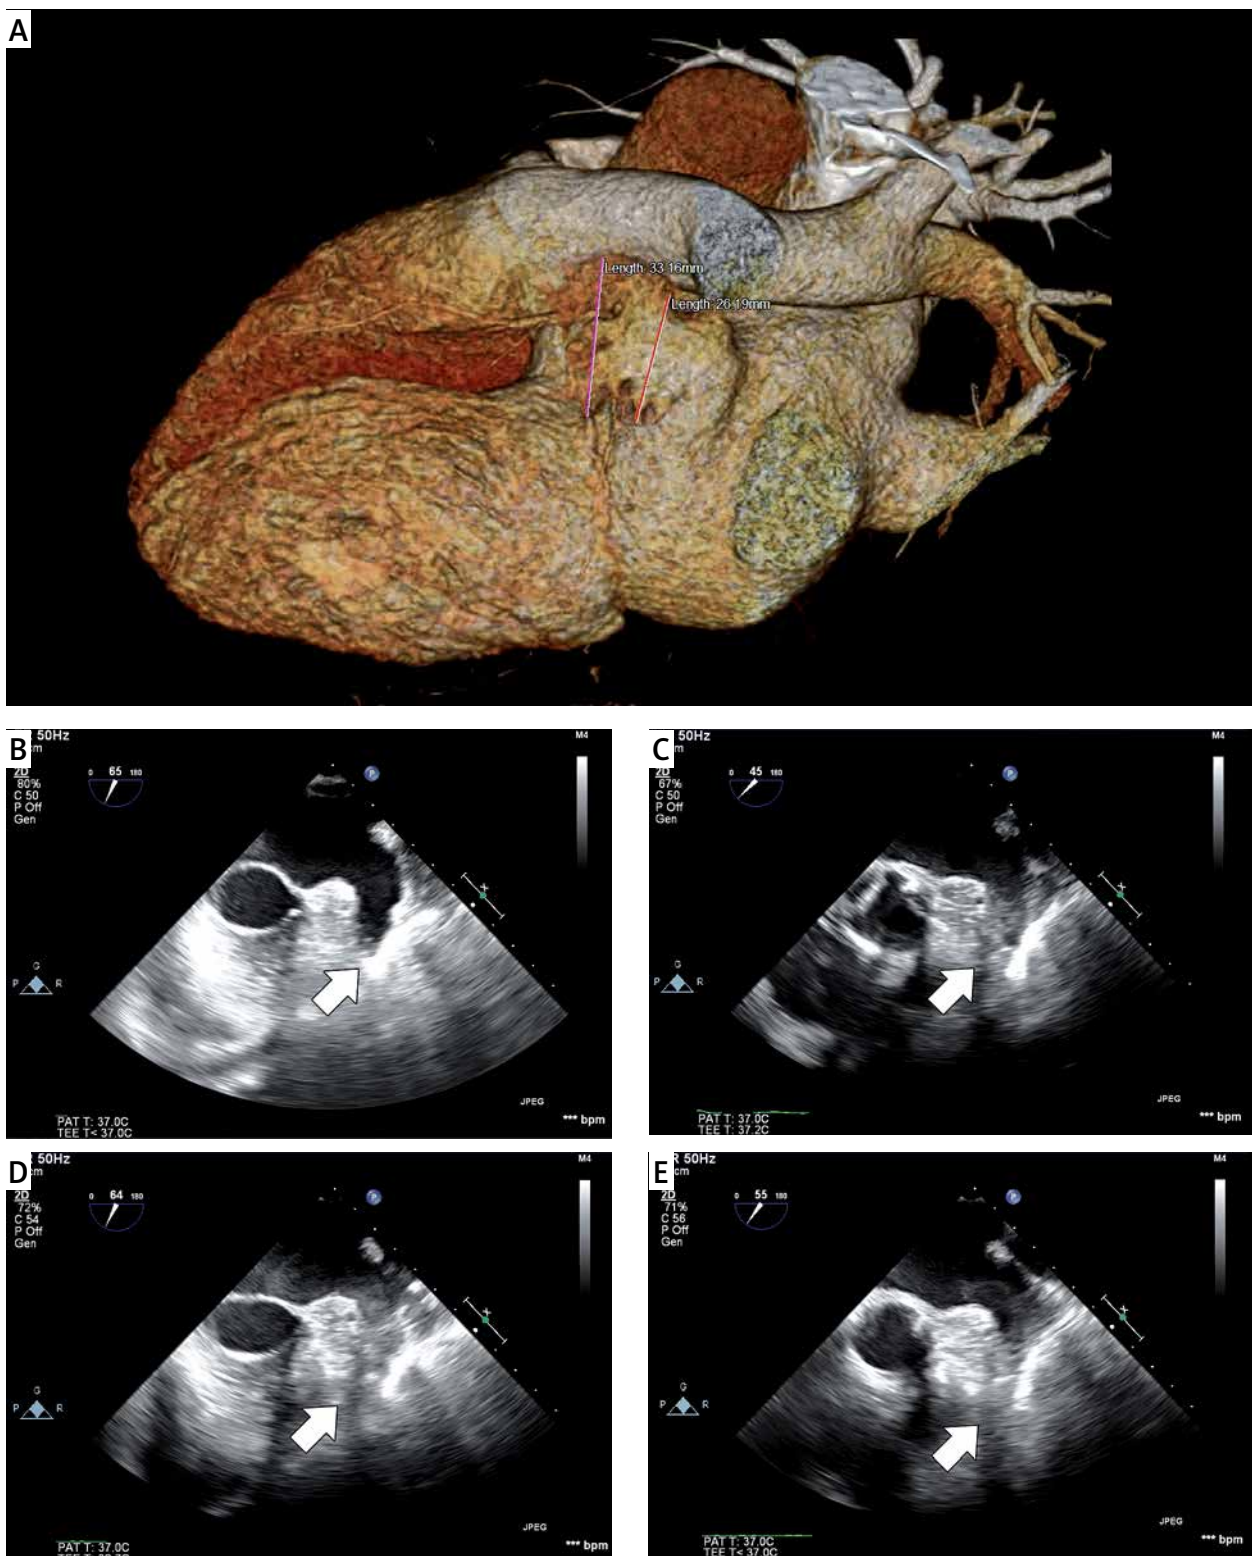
A – 3D computed tomography reconstruction scan with measurements of the left atrial appendage (LAA), B – transesophageal echocardiogram (TEE) at 3:57 PM with no thrombus in LAA (arrow), C – TEE at 4:27 PM with a fresh thrombus formed in less than 20 min, D – TEE at 4:31 PM with a solid fresh thrombus in the LAA, E – TEE the next day with partial dilution of the LAA thrombus
